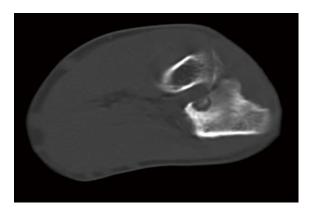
The nidus is computed tomography-guided surgically removed.
